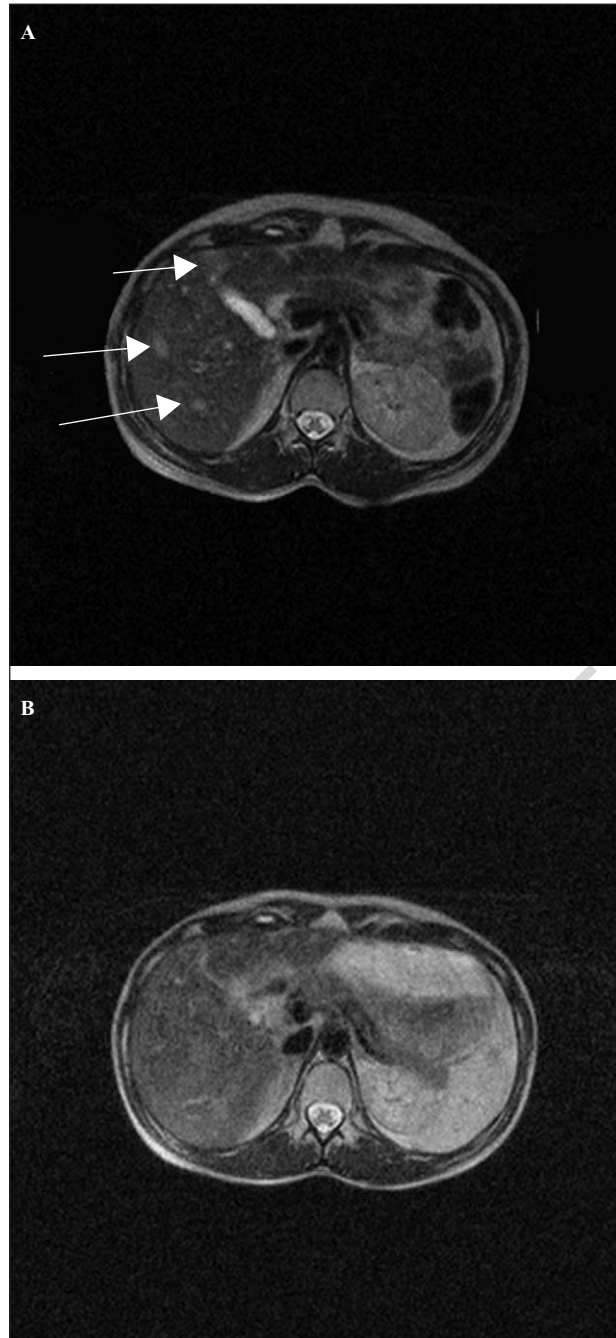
A MRI scan of patient P before (A) and at 6 months post immunotherapy initiation (B). The metastatic lesions are indicated by pointers.
